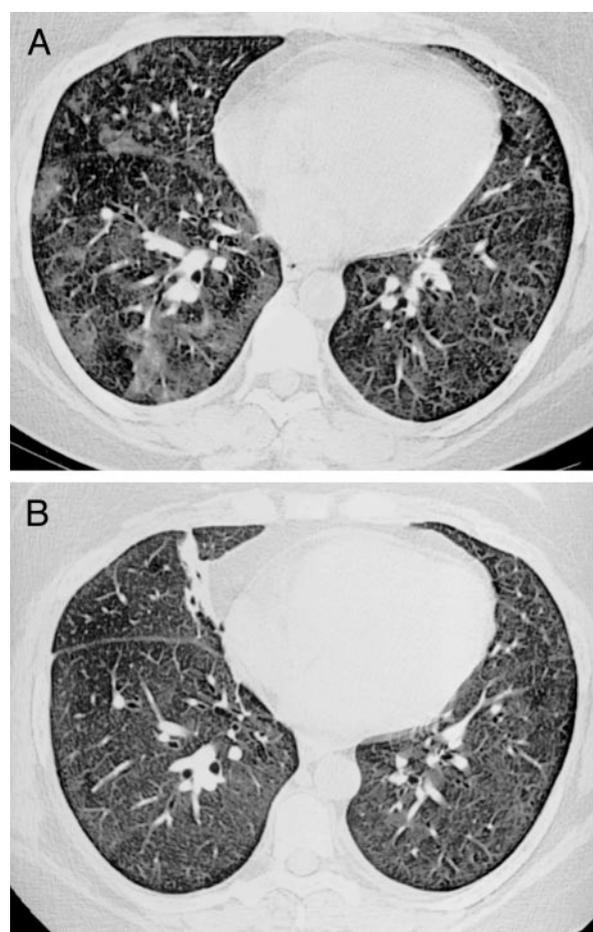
A 41-year-old woman, a smoker, with RB-ILD. *Top, A:* HRCT scan performed 3 days before she underwent surgical lung biopsy demonstrates patchy ground-glass opacities in both lungs, which are more pronounced on the right side. *Bottom, B:* HRCT scan performed 7 weeks later demonstrates substantial improvement in lung infiltrates (postoperative change seen in the right middle lobe). The patient had been treated with prednisone, beginning at 40 mg/d and tapered down to 5 mg/d, along with cessation of smoking.
